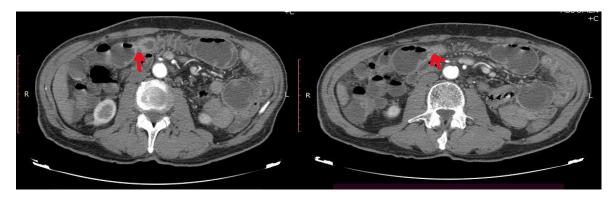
CT view of the tumor.
